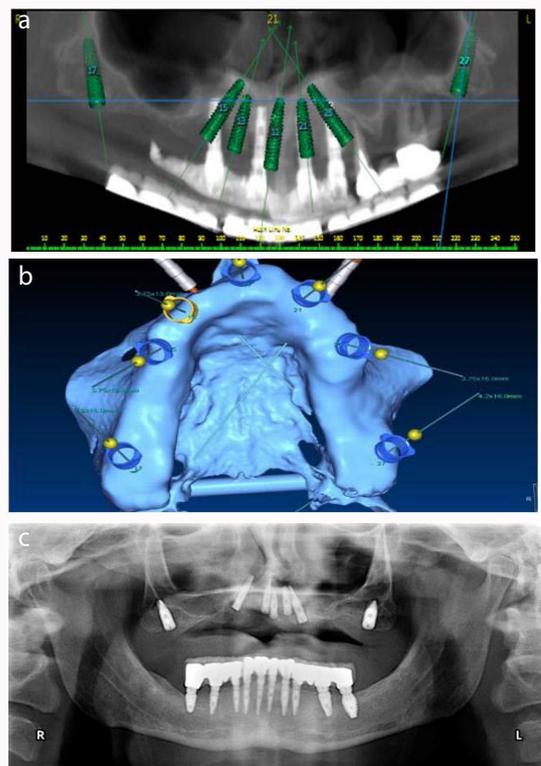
(a) Computer aided design of upper jaw implantation utilizing bilateral pterygoid implants with five anterior conventional implants. The path of insertion of the new implants is drawn and superimposed over the existing failing implants and teeth of the patient. (b) Hard tissue supported surgical guided. Note the two anterior screws that fixate the guide to the maxillary basal bone during the implantation. (c) Postoperative panoramic X-ray showing implants in place.
